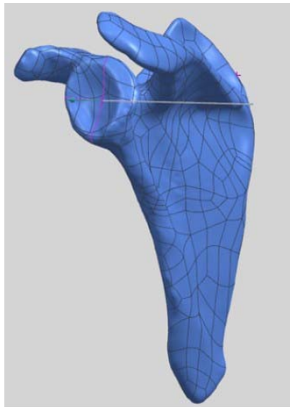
Representative 3D model of a scapula created from CT scans. The white line represents Friedman's line.
